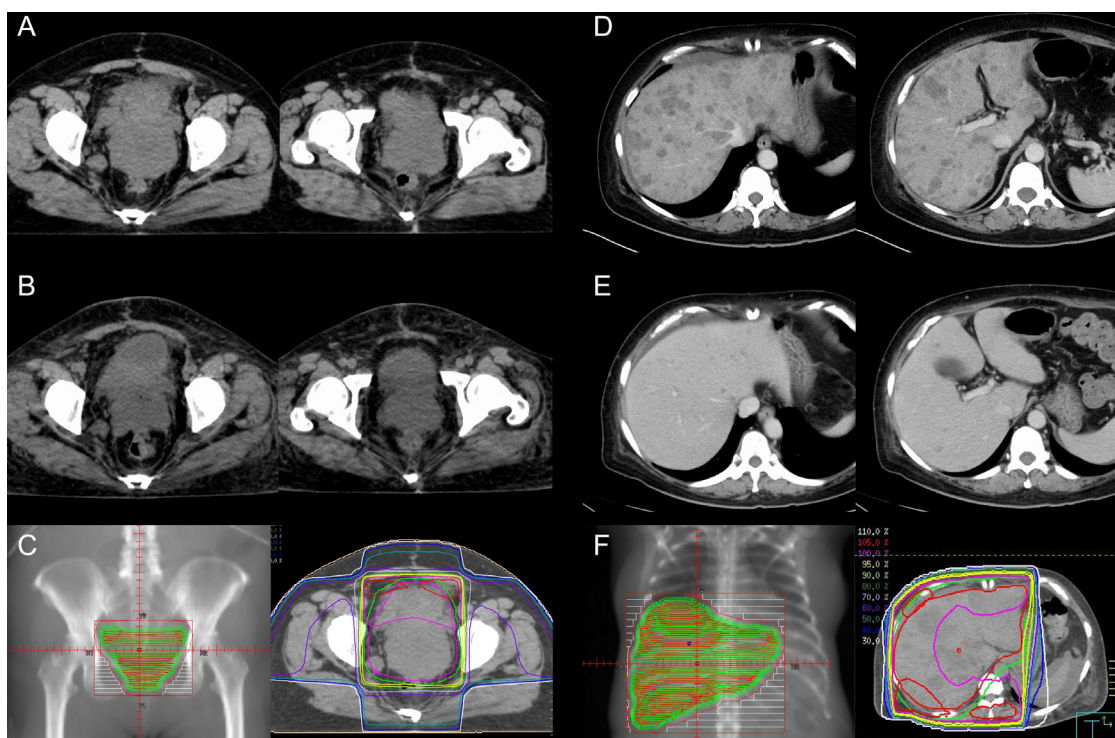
Axial computed tomography (CT) of the locally recurrent lesion (A) before and (B) 2 months after radiation therapy. Axial CT of the liver (D) 3 weeks before and (E) 2 weeks after whole-liver radiation therapy. Radiation therapy plan for (C) the locally recurrent lesion and (F) the liver metastases.
